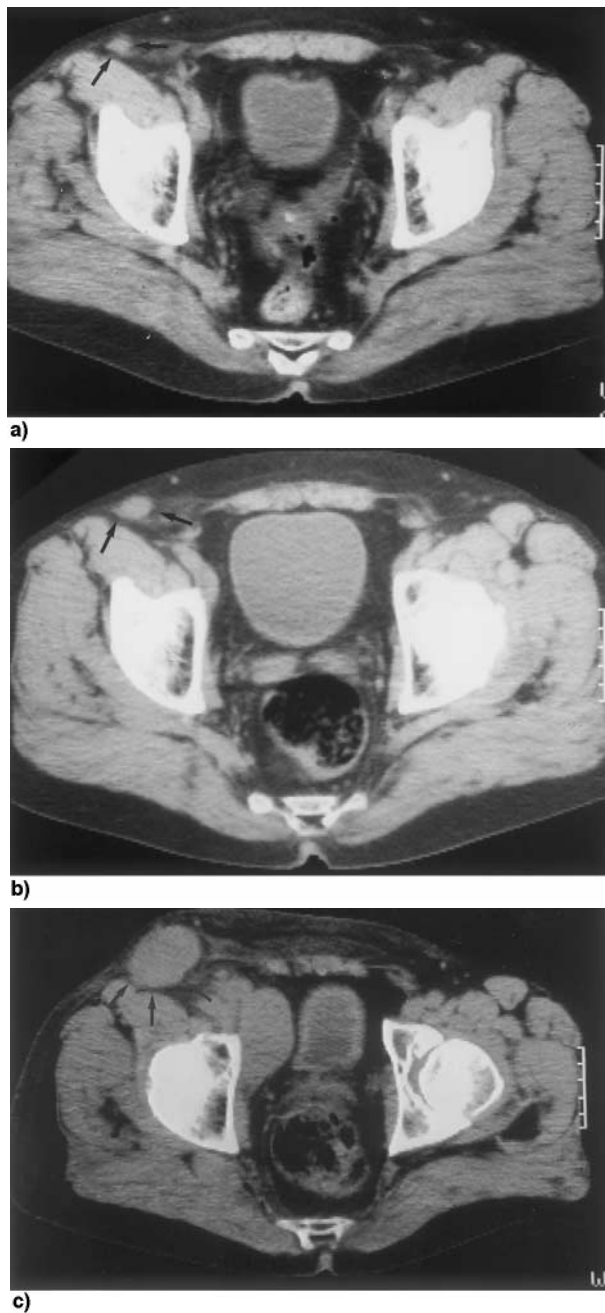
Evaluation of the CT images in a patient with aggressive lymphoma before (CT 1), during (CT 2) and after (CT 3) therapy. a) CT 3 and b) CT 2 show a residual mass in the right groin (arrows) after completion and after half of the chemotherapy course, respectively. c) CT 1 shows an enlarged lymph node (arrows) before treatment, corresponding to the residual mass on CT 3 and CT 2. This patient also presented with enlarged lymph nodes in the pelvis at diagnosis.
